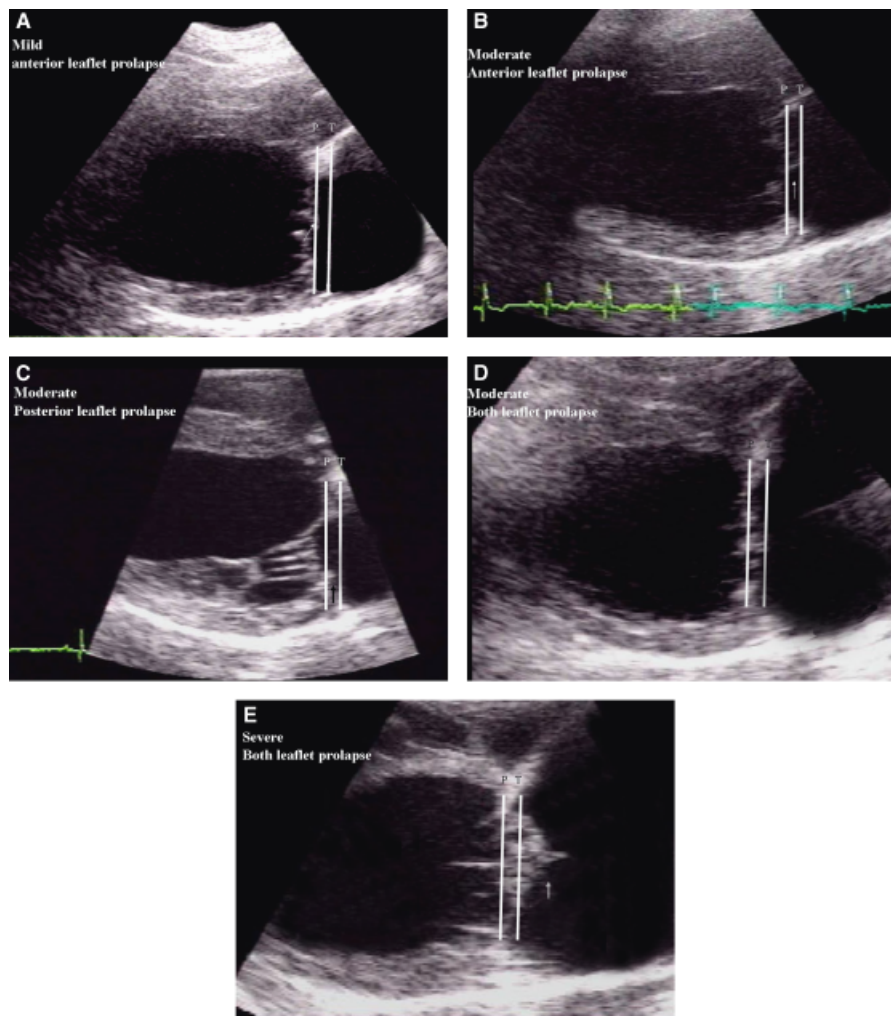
(A, B, C, D, E) Right parasternal long axis four-chamber view: (A) Mild mitral valve prolapse was assessed by the protrusion of one of both leaflets to line P. (B, C, D) Moderate mitral valve prolapse was assessed by the protrusion of one or both leaflets between line P and line T; In D note also the thickening of cordae tendinae. (E) Severe mitral valve prolapse was assessed by the protrusion of one or both leaflets over line T. The arrows outline the severity of mitral valve prolapse and the affected leaflet.
